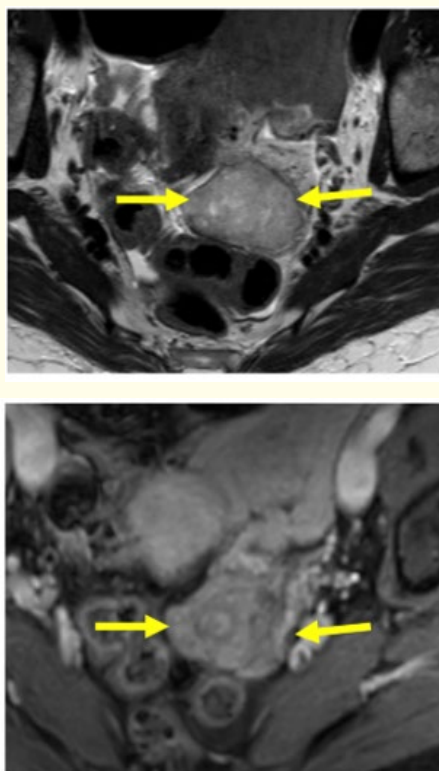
Axial T2 weighted image shows a lobulated mass with mildly heterogeneous high signal intensity. Axial postcontrast T1-weighted image shows heterogeneous enhancement.
